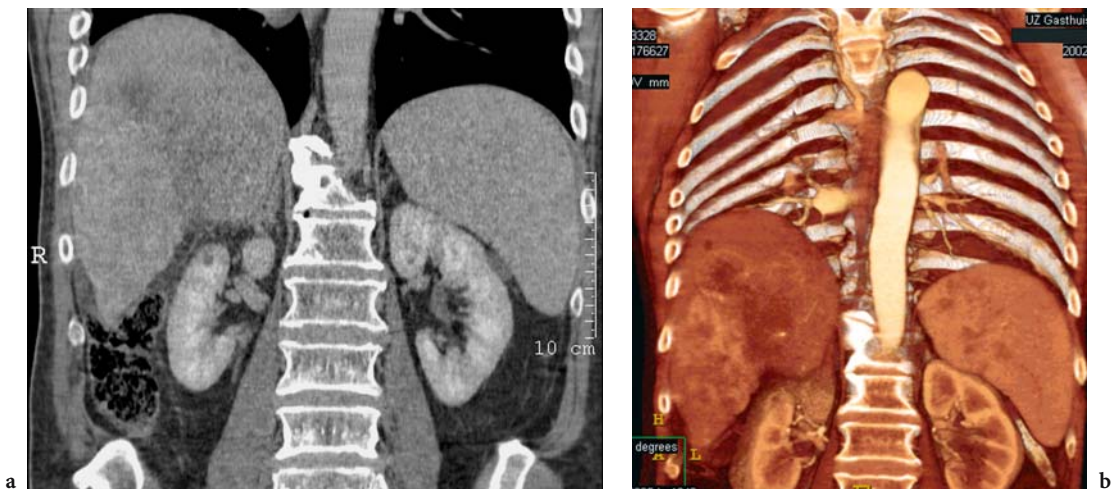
A MDCT of the diaphragm a frontal and b 3D reconstructions. Patient with a large malignant tumor in the right lobe of the liver causing elevation of the right hemidiaphragm. Note that the diaphragmatic crura are visible as smooth linear opacities originating from the central tendon and oriented downward, parallel to the vertebral column. The CT protocol: acquisition 16×0.75 mm; pitch 1.75; slice thickness for frontal reformation 1 mm
